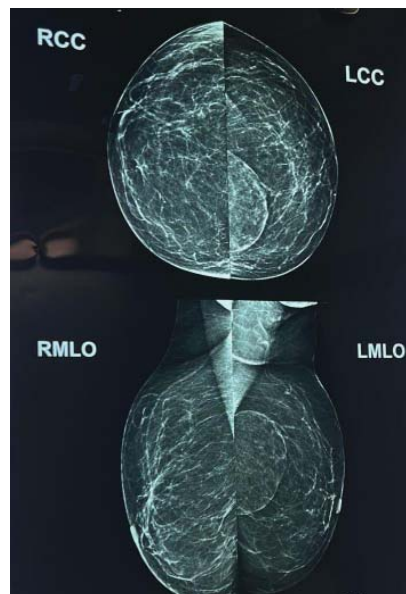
An x-ray mammogram showing the 'breast within the breast' lesion of the left side.
